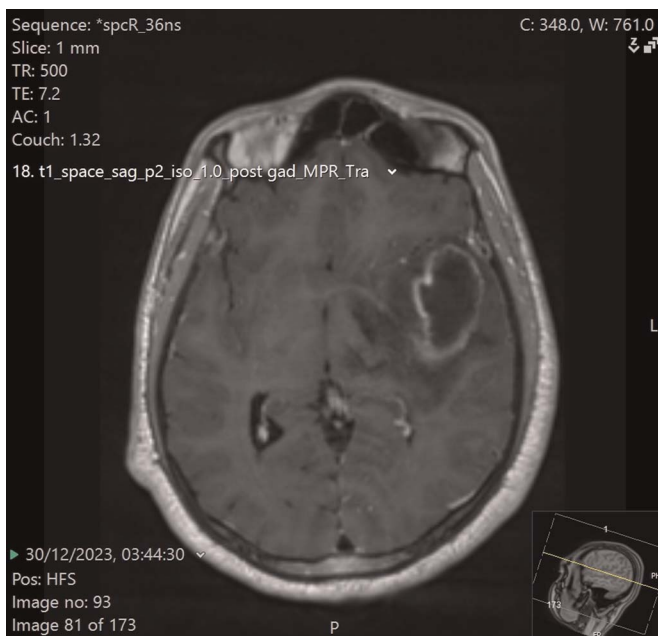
MRI image of left temporal brain abscess. MRI, magnetic resonance imaging.
